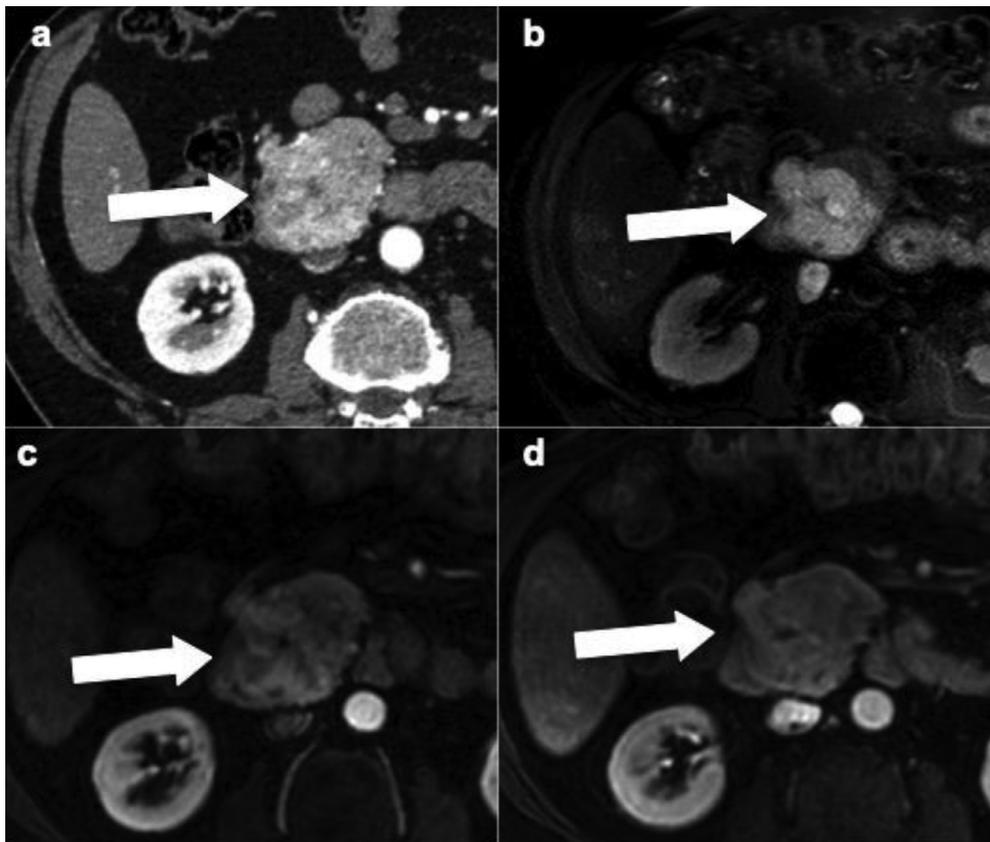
Pancreatic extra gastrointestinal stromal tumor (EGIST) in a 65-year-old male patient. Axial enhanced CT image (a) obtained during the arterial phase shows a hyperenhanced lesion (arrow) in the pancreatic head. The lesion is bright on fat-suppressed T2-weighted MR image (b) and shows enhancement on contrast-enhanced fat-suppressed T1-weighted MR image obtained during the arterial phase (c), which persists in the portal venous phase (d).
